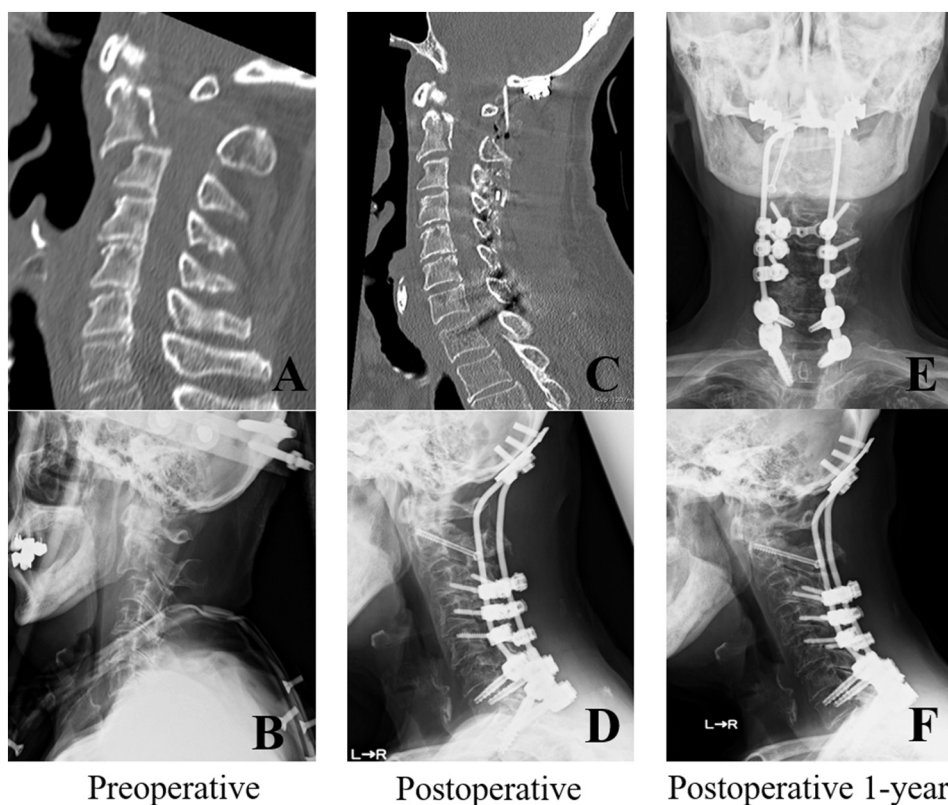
Preoperative CT imaging of the cervical spine showing a fracture-dislocation of C2 (A: sagittal view). We performed fixation with a Halo-vest (B: lateral view). Posterior fixation of O-T1 was performed (C: sagittal view D: lateral view). Radiographs 1 year after surgery showing bone union of fracture location and no mechanical failure (E: anterior-posterior view F: lateral view).
